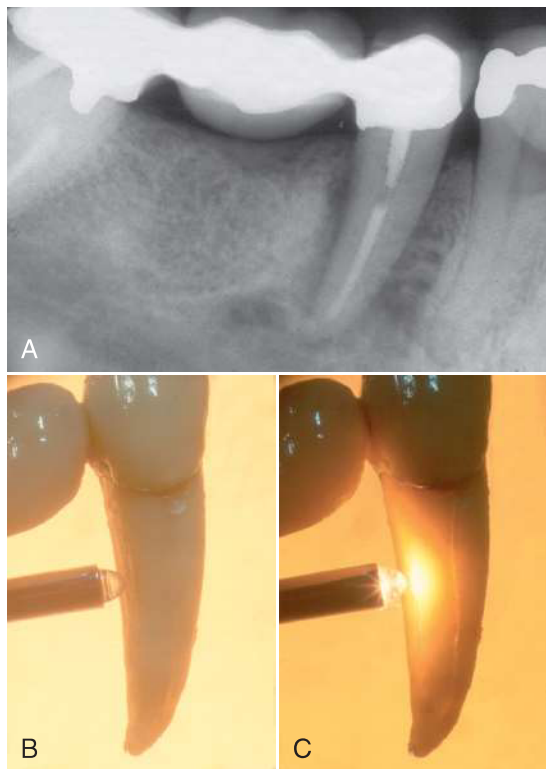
Radiographic presentation of VRF-associated bone loss. A second right mandibular bicuspid was endodontically treated and restored using a short post. Two years later the patient started experiencing discomfort and sensitivity upon chewing. Initially no radiographic signs were present. This lasted for 9 months until a radiograph (A) revealed an extensive bone resorption and the tooth extracted. A, A large radiolucent lesion was present along the root on the distal side. B, The tooth was extracted, but the buccal VRF was not readily evident. C, Transillumination with an intense but small light source was used after extraction to clearly demonstrate the VRF. (Courtesy Dr. Ramy Levi, Israel.)
